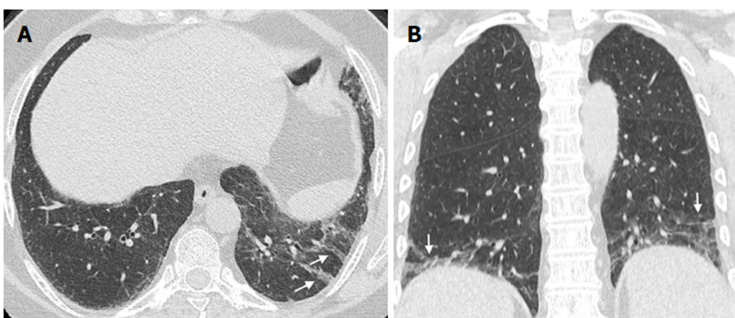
Nodules. A 64-year-old female patient with common variable immunodeficiency disorder. High-resolution computed tomography shows multiple, small nodules with peribronchial and perifissural location in the upper and lower lobes of both lungs (arrows). A diagnosis of granulomatous and lymphocytic interstitial lung disease was subsequently made.
